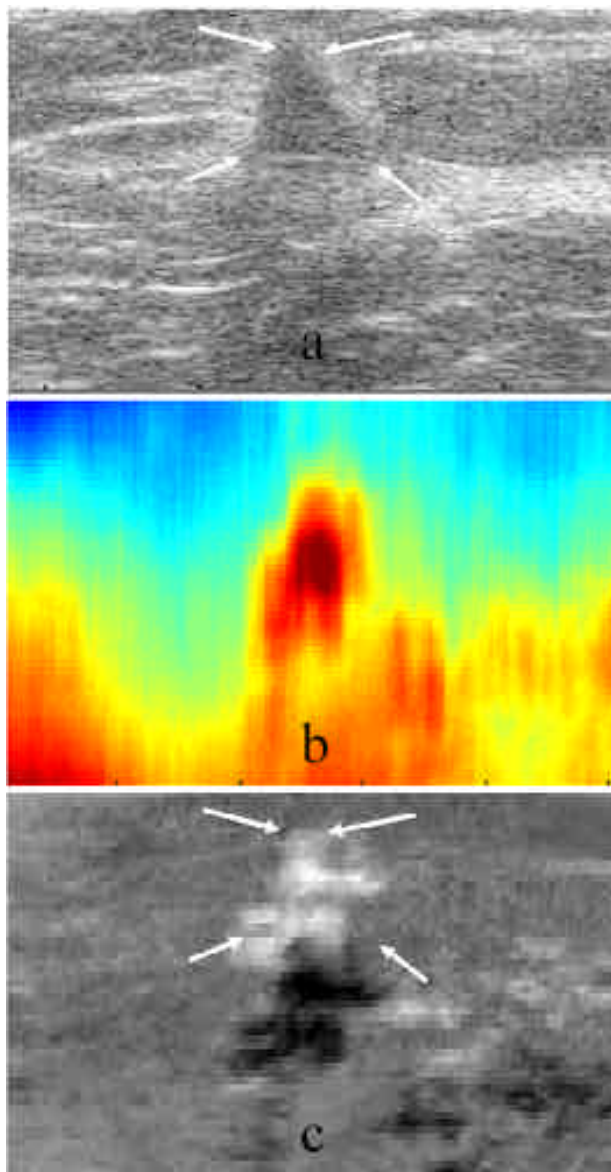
Sonogram (a), displacement map (b) and elastogram (c) of a 10 mm IDC (48 years old patient). The displacement map shows a region of very high motion around the lesion. The lesion appears very bright (soft) on the elastogram.
